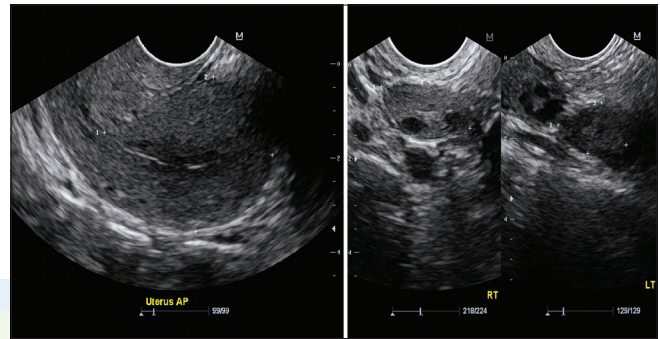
Transvaginal sonogram of Case 3 showing normal results
